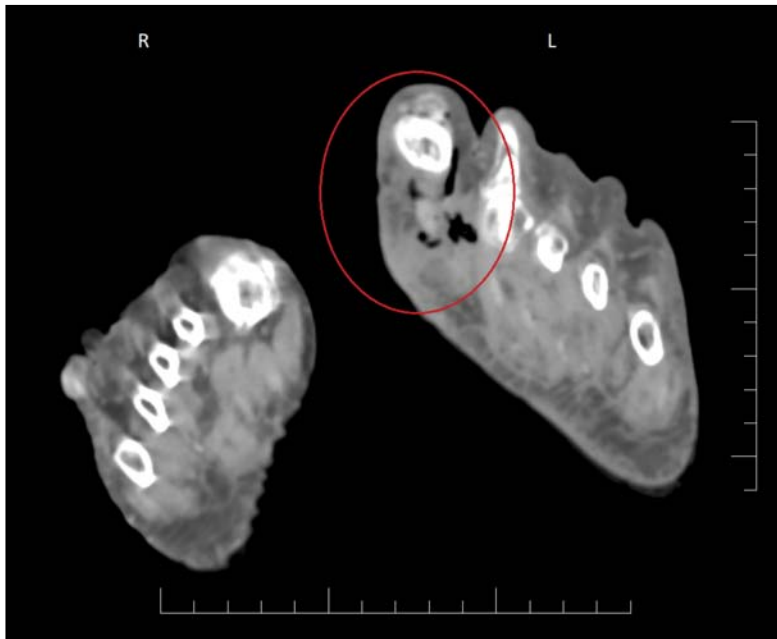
CT scan of feet: edema and gas bubbles around the head of the first metatarsus of the left foot (red circle)
